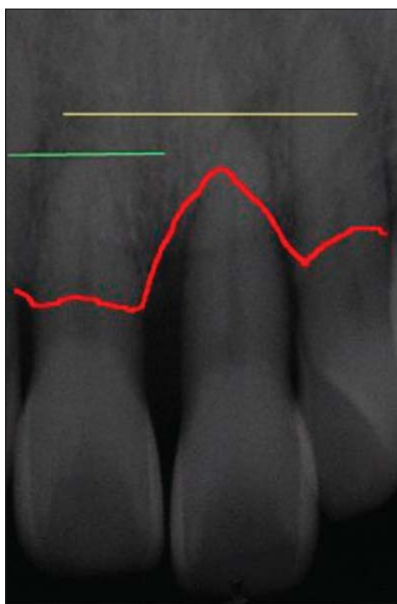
(Right) A radiograph obtained after forced eruption. The new bone level shows the result of forced eruption.
